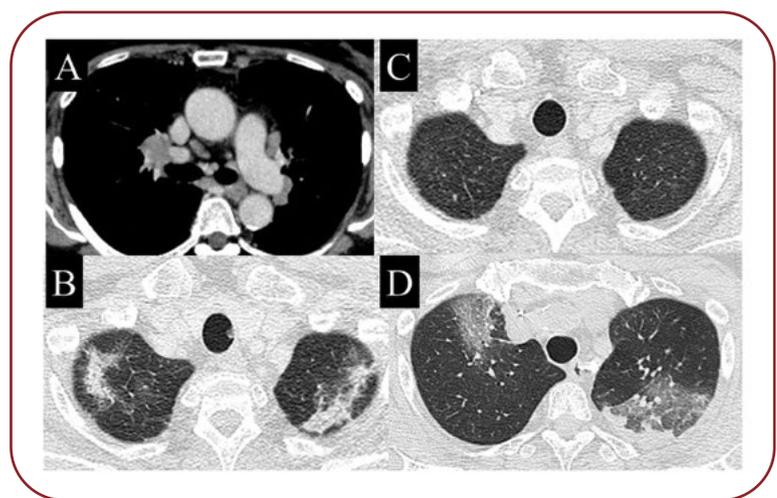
Chest CT scan at the first presentation revealed bilateral hilar and mediastinal lymphadenopathy (A) with ground glass opacities (GGOs) in both upper lobe of the lung (B); CT one month after the first admission showed disappearance of ground glass opacities (C); appearance of infiltrative opacities in the upper lobes of both lungs was found on the chest CT scan one year after the first visit (D)
